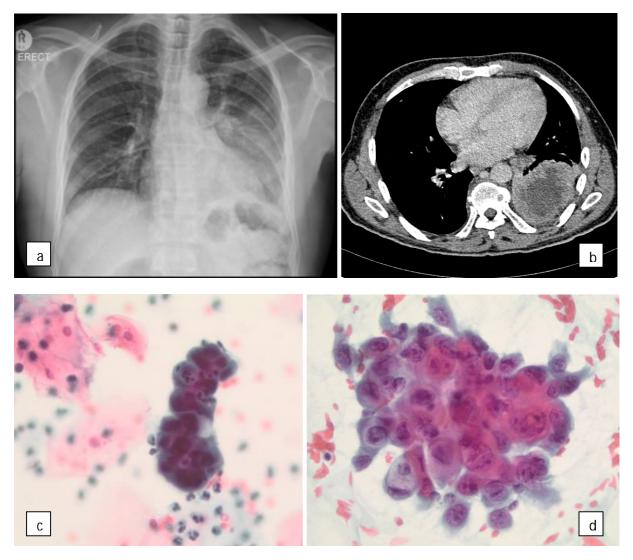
Mass in left hilum and throughout left upper lobe with associated collapse of the left lower lobe on chest X-ray (a) and CT (b). Sputum - malignant. Balls of cells present with vacuolated cytoplasm suggestive of adenocarcinoma (c). TTNA - Non-small cell carcinoma, favour a squamous cell carcinoma or adenosquamous carcinoma (d).
